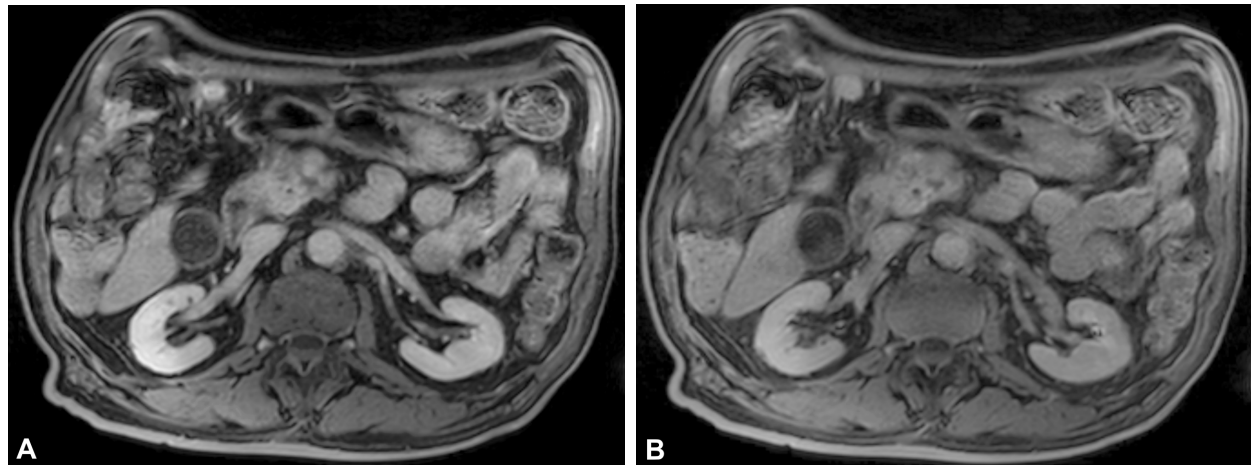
MRI aspects of a pancreatic tumor of the head and uncinated process: (A) Arterial phase; (B) Venous phase. MRI: Magnetic resonance imaging.
